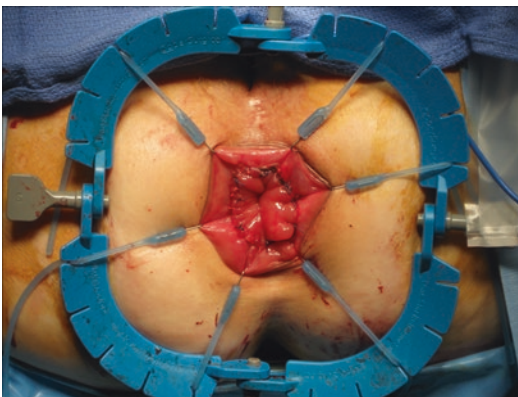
Lone Star Retractor (Cooper Surgical, Trumbull, CT)
